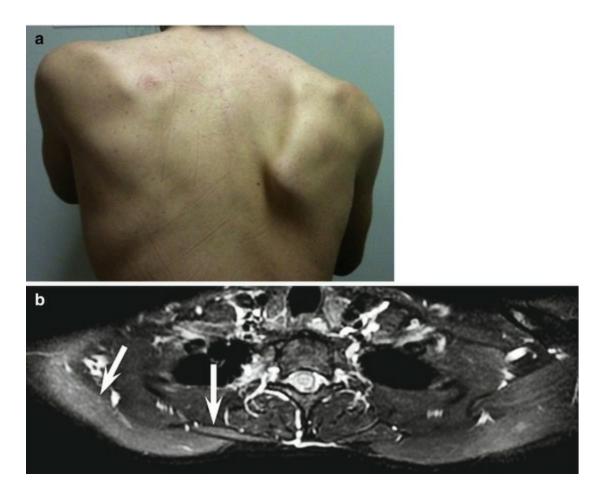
A 19-year-old man with Parsonage-Turner Syndrome. (a) Photograph shows right scapular winging. (b) Axial water-imaging IDEAL MRI shows edema in the right trapezius and rhomboid muscles (*arrows*)
